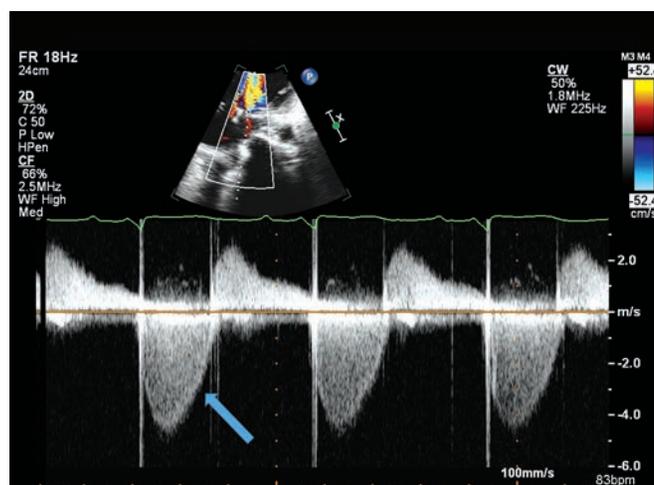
This image demonstrates the continuous wave Doppler through the MV on the TTE. The blue arrow shows the MR envelope. Note that the MR jet is almost as dense as the forward flow, revealing significant MR. The envelope is early peaking and triangular shaped indicating elevated left atrial pressures.
